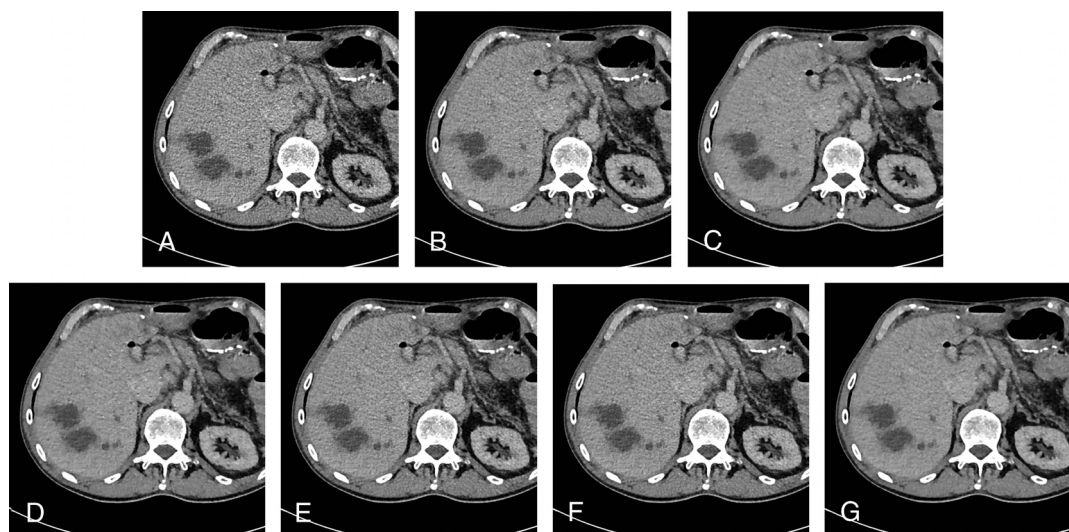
Transverse CT images in a 66-year-old male patient with liver metastases from colorectal cancer reconstructed with FBP (A), SAFIRE strength level 3 (B), 4 (C), 5 (D), and ADMIRE strength level 3 (E), 4 (F), 5 (G). Note the reduced IR-specific artifacts on ADMIRE as compared with SAFIRE images.
